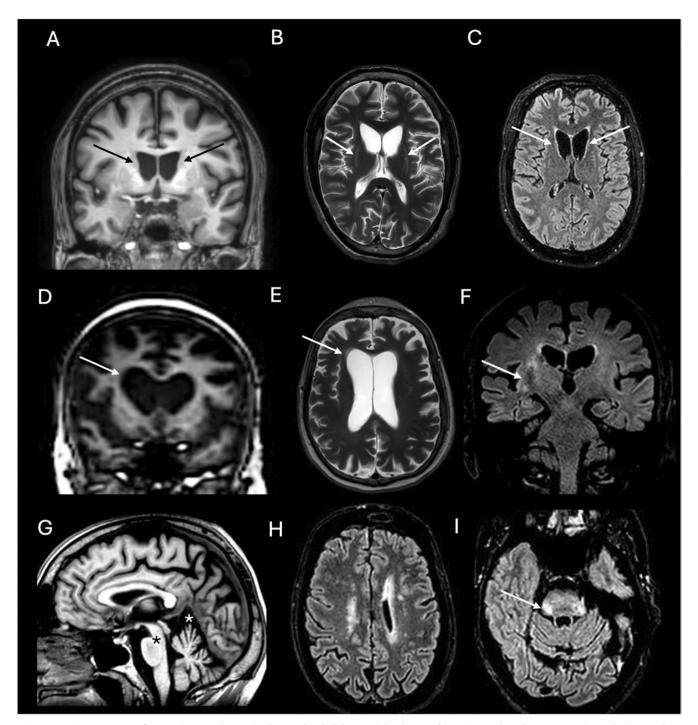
MRI images from patients with genetic choreas (A–I). (A) T1-weighted MRI of a patient with early-stage Huntington's disease showing mild caudate atrophy (arrows). (B) T2-weighted MRI of a patient with the Westphal variant of Huntington's disease showing characteristic hyperintensity in the putamen associated with caudate atrophy. (C) FLAIR MRI demonstrating caudate atrophy in a patient with neuroacanthocytosis due to a VPS13A mutation. (D, E) Coronal T1-weighted and axial T2-weighted images showing asymmetric atrophy, predominantly in the right frontal lobe, in a patient with a C9orf72 mutation, chorea, and frontotemporal cognitive decline. (F) FLAIR MRI of a patient with SCA17 presenting with ataxia, parkinsonism, and chorea, showing a right putaminal rim and cerebellar and caudate atrophy. (G–I) MRI of a patient with DRPLA: (G) T1-weighted image showing hypointensity in the pons and cerebellar atrophy, (H) FLAIR image showing characteristic white matter hyperintensities, and (I) FLAIR image showing hyperintensity in the superior cerebellar peduncle and brainstem pathways.
